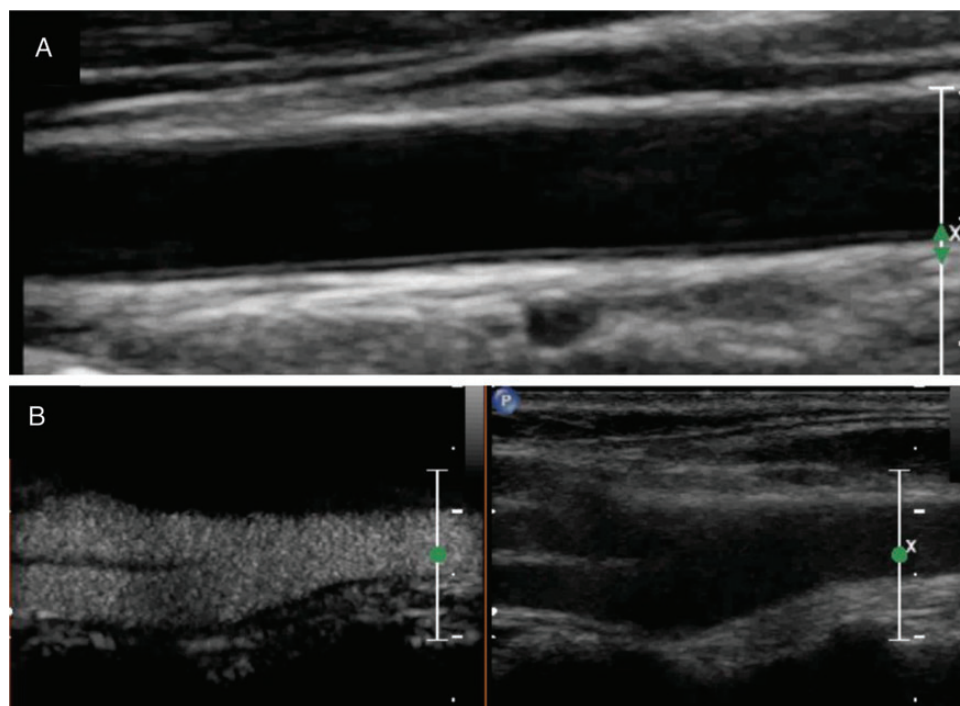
Carotid B-mode ultrasound and CEUS in a 34-year-old woman with Takayasu arteritis (Case 5 from Table 1). (A) Longitudinal B-mode ultrasound demonstrating a normal carotid wall thickness in the CCA. (B) Longitudinal side-by-side carotid CEUS (left panel) and B-mode ultrasound (right panel) of the carotid bifurcation. There were no vascular lesions, and no contrast enhancement at the vascular wall, suggesting the absence of pathological wall vascularization.
